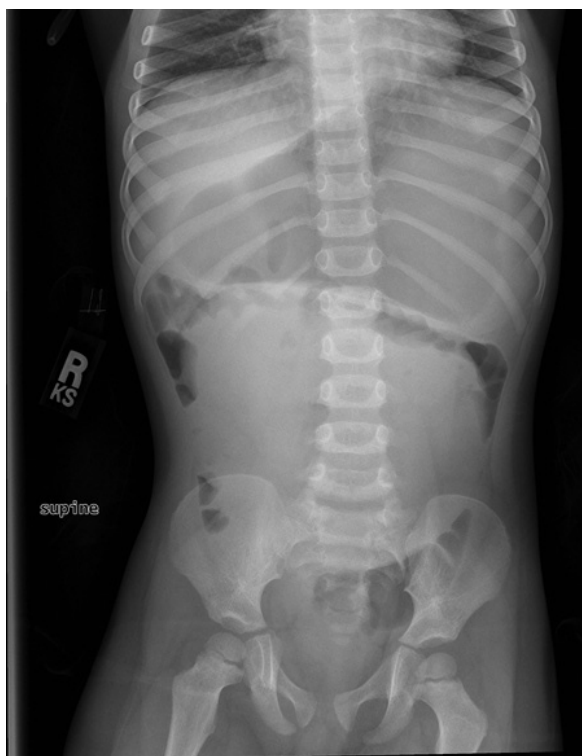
4-year-old boy with small bowel polyps. Frontal, supine radiograph of the abdomen demonstrates a large soft tissue mass in the central abdomen, displacing bowel loops peripherally. The stomach is moderately distended.
